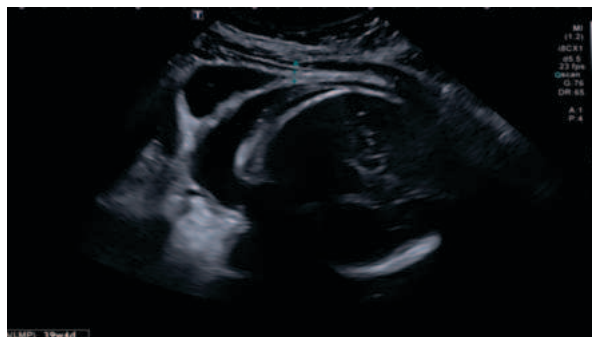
Ultrasonography at 39 weeks and 4 days gestation
